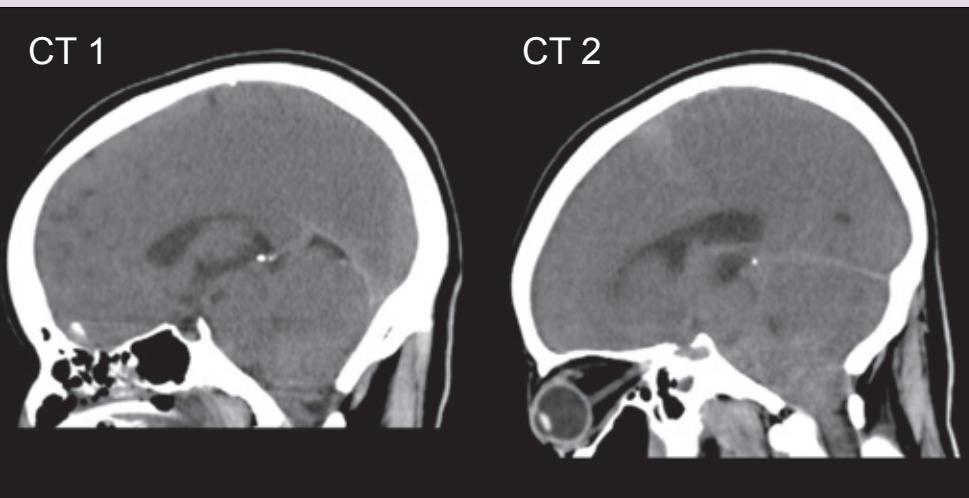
Midline sagittal sections from the initial and subsequent CT studies showing development of tonsillar herniation.
